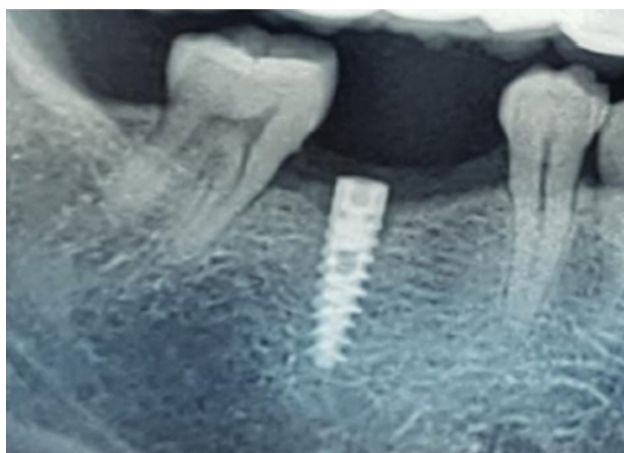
A follow-up radiograph three months after implant placement.
